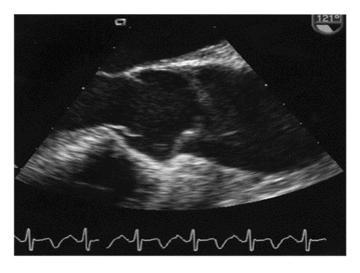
Dissection of the ascending aorta seen in a transesophageal long axis-view at 121° in systole. Note mobile flap changing configuration during the cardiac cycle (compare Figure 12.2), and aortic dilation. (Reproduced from Flachskampf and Daniel. Cardiology Clinics 2000; 18:807–17.² © 2000 with permission from Elsevier.)
